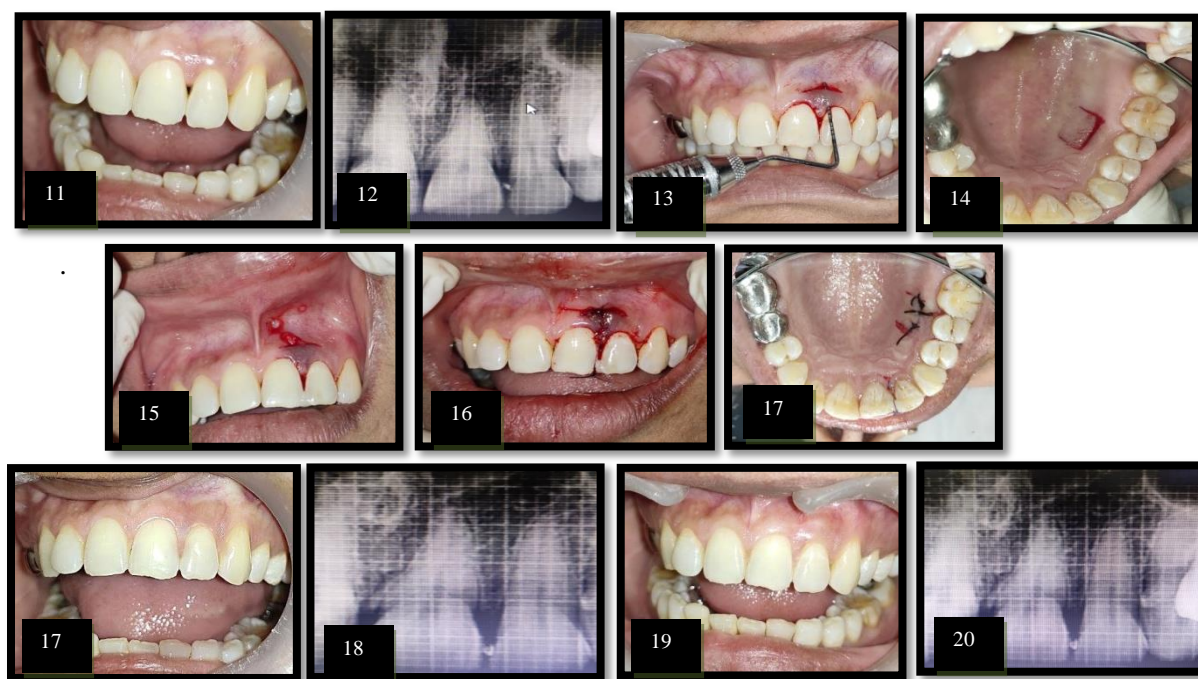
(11) Pre treatment photographs. (12) Radiographic measurement of tip of papilla to bone crest. (13) Tunnel preparation. (14) Incision given (Trap door Tech.). (15) SCTG was tucked into recipient site. (16) Graft secured with suspensory sutures. (17) Sutures taken (palatal side). (18-19) Follow-up after 3 months. (20-21) Follow-up after 6 months.
